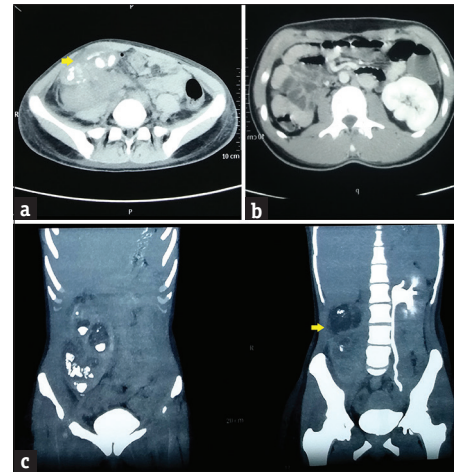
Right ectopic kidney seen on (a) Noncontrast computed tomography occupying the right iliac fossa with extensive perinephric stranding, anteriorly facing pelvis (arrow) filled with calculi and thinned out parenchyma (b) Contrast enhanced computed tomography showing the striking absence of kidney in right renal fossa (c) computed tomography urogram showing absence of contrast excretion in the dilated ectopic kidney (arrow) with normal drainage in contralateral kidney
